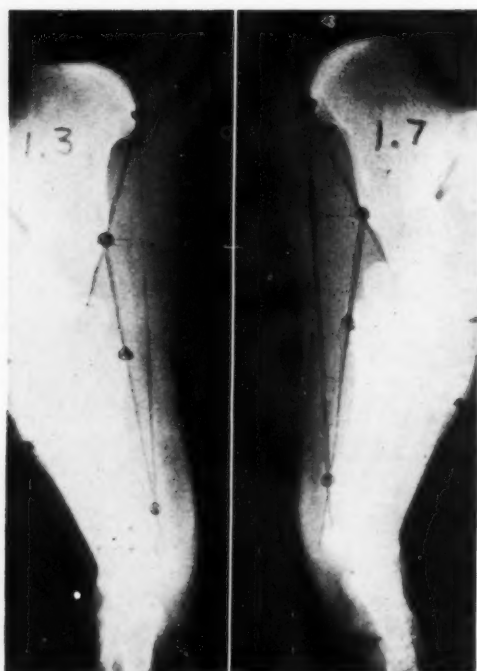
Roentgen measurement of the arch during repose.
